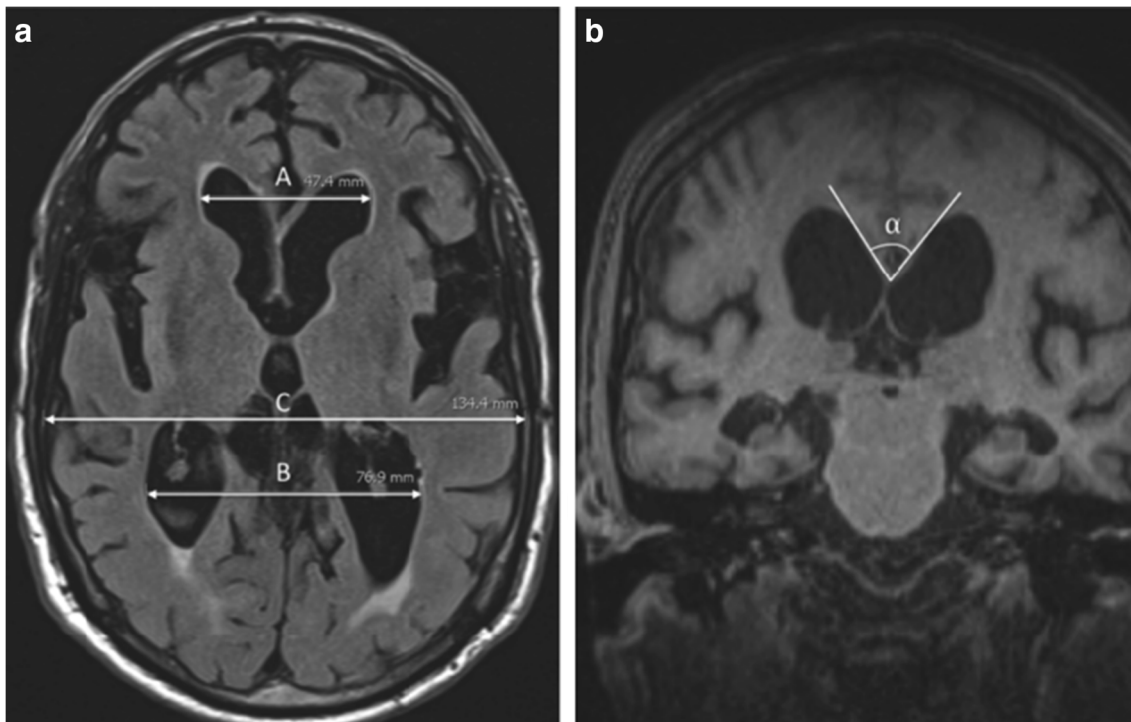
MRI images of an 83-year-old male with iNPH. a An axial T2-FLAIR image demonstrating enlarged ventricles with Evan's ratio (A/C) of 0.35 and a frontal and occipital horn ratio (A+B)/2C of 0.46. b A coronal T1-weighted image demonstrating a callosal angle, α , of 70% at the level of the posterior commissure. Reproduced from Isaacs et al. [52] with permission).
